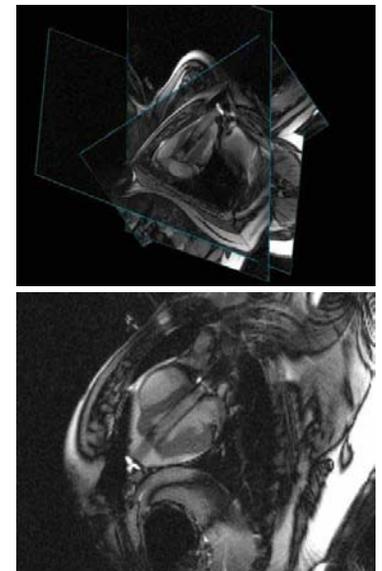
a, b) Realtime MRI guided trans apical aortic valve implantation.
